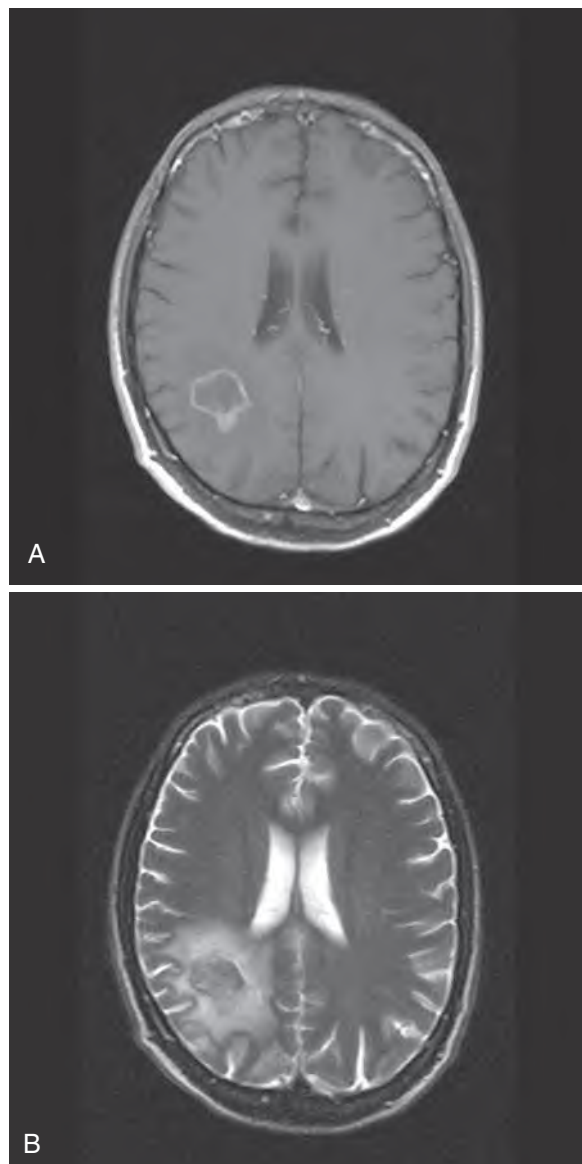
Brain magnetic resonance images of a 50-year-old man with primary central nervous system lymphoma. (A) A 2-cm ring-enhancing lesion is present in the right parietal lobe, surrounded by edema. (B) The T2-weighted image shows low signal intensity centrally, which is more consistent with cellular proliferation than with an infectious process.
